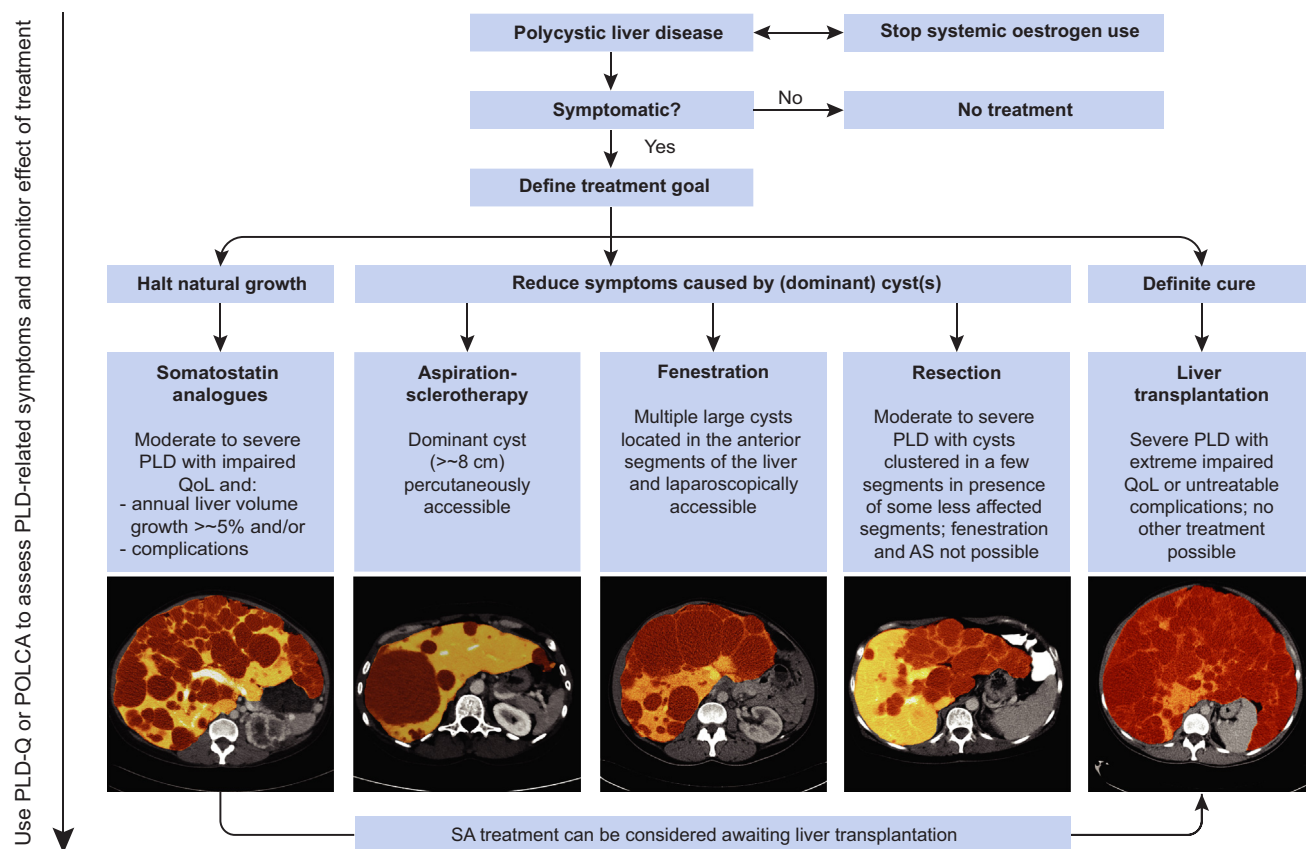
Treatment algorithm for polycystic liver disease subdivided by treatment goal. Treatment is only indicated in symptomatic patients and choice of treatment depends on expertise and availability in the local centre. The transversal CT images serve to show the phenotype applicable to each type of treatment. The liver is accentuated; cysts are coloured dark whereas the lighter parts resemble normal liver parenchyma. AS, aspiration sclerotherapy; CT, computed tomography; PLD, polycystic liver disease; QoL, quality of life; SA, somatostatin analogues.
